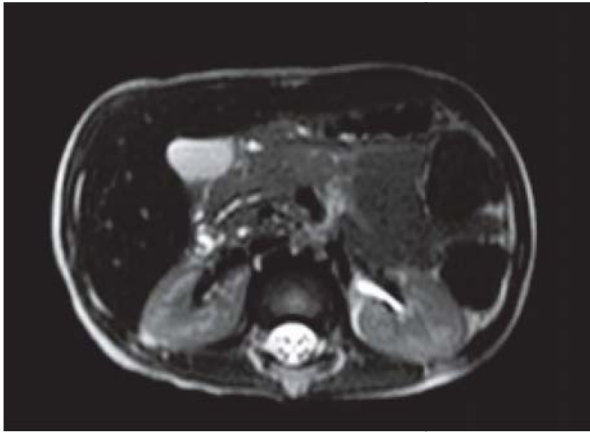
T2W MRI MRCP image showing drainage of main pancreatic duct into the second part of duodenum
